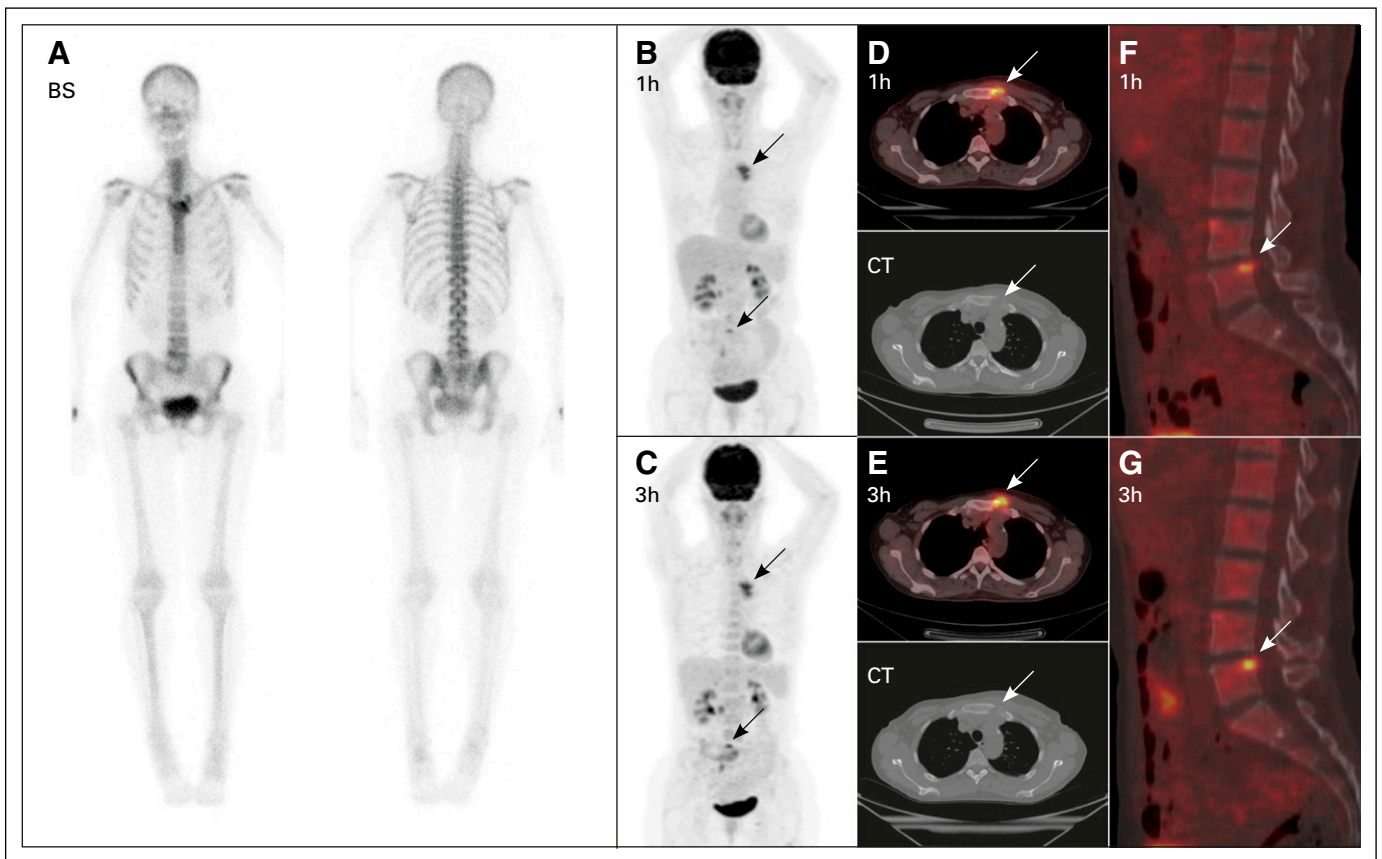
Example of a patient falsely categorized by [^{18}F]fluorodeoxyglucose (FDG)-positron emission tomography (PET)/computed tomography (CT) as having bone recurrence in the sternum and lumbar spine. After these images were taken, a biopsy was taken from the patient's sternum. The biopsy was inconclusive, and the patient was diagnosed with Tietze syndrome. She did not start treatment of any kind. Clinical follow-up without further imaging revealed no recurrence. (A) Bone scintigraphy (BS) in the anterior and posterior projection. Maximum intensity projection images of FDG-PET/CT at (B) 1 hour (1h) and (C) 3 hours (3h) after FDG injection. Transaxial images at (D) 1 hour and (E) 3 hours after injection and low-dose CT scans showing a lesion in the sternum (arrow), categorized as bone recurrence on FDG-PET/CT. Sagittal images at (F) 1 hour and (G) 3 hours after injection of a lesion in L5 in the lumbar spine (arrow), categorized as false positive on FDG-PET/CT.
